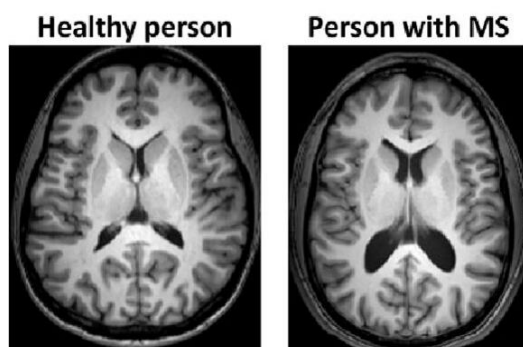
MRI scans comparing brain of a person with and without MS³.
